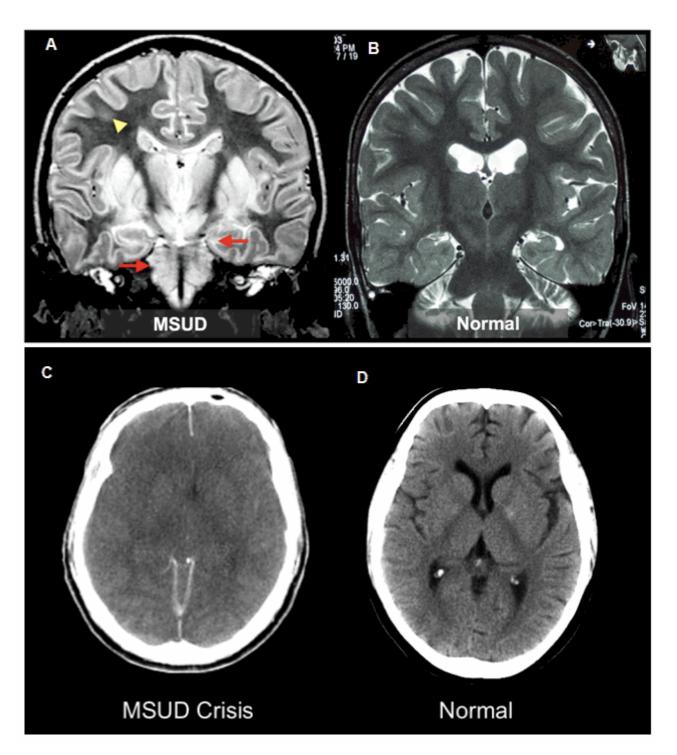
A. Coronal T₂-weighted MRI from a Mennonite boy age five years during an acute metabolic crisis. Diffuse gray matter swelling and signal hyperintensity (on T₂-weighted and FLAIR images) involve the cortical mantle, basal ganglia nuclei, hippocampus, and brain stem. Patches of increased T₂-weighted signal are also seen in white matter of the centrum semiovale (yellow arrowhead). Swelling of the pons and medial temporal lobes (red arrows) increases the risk for transtentorial herniation and occlusion of the posterior cerebral circulation, particularly if serum osmolarity decreases. On diffusion-weighted imaging, areas of T₂-weighted signal hyperintensity have restricted water diffusion, indicating acute cytotoxic edema. These changes are fully reversible.
